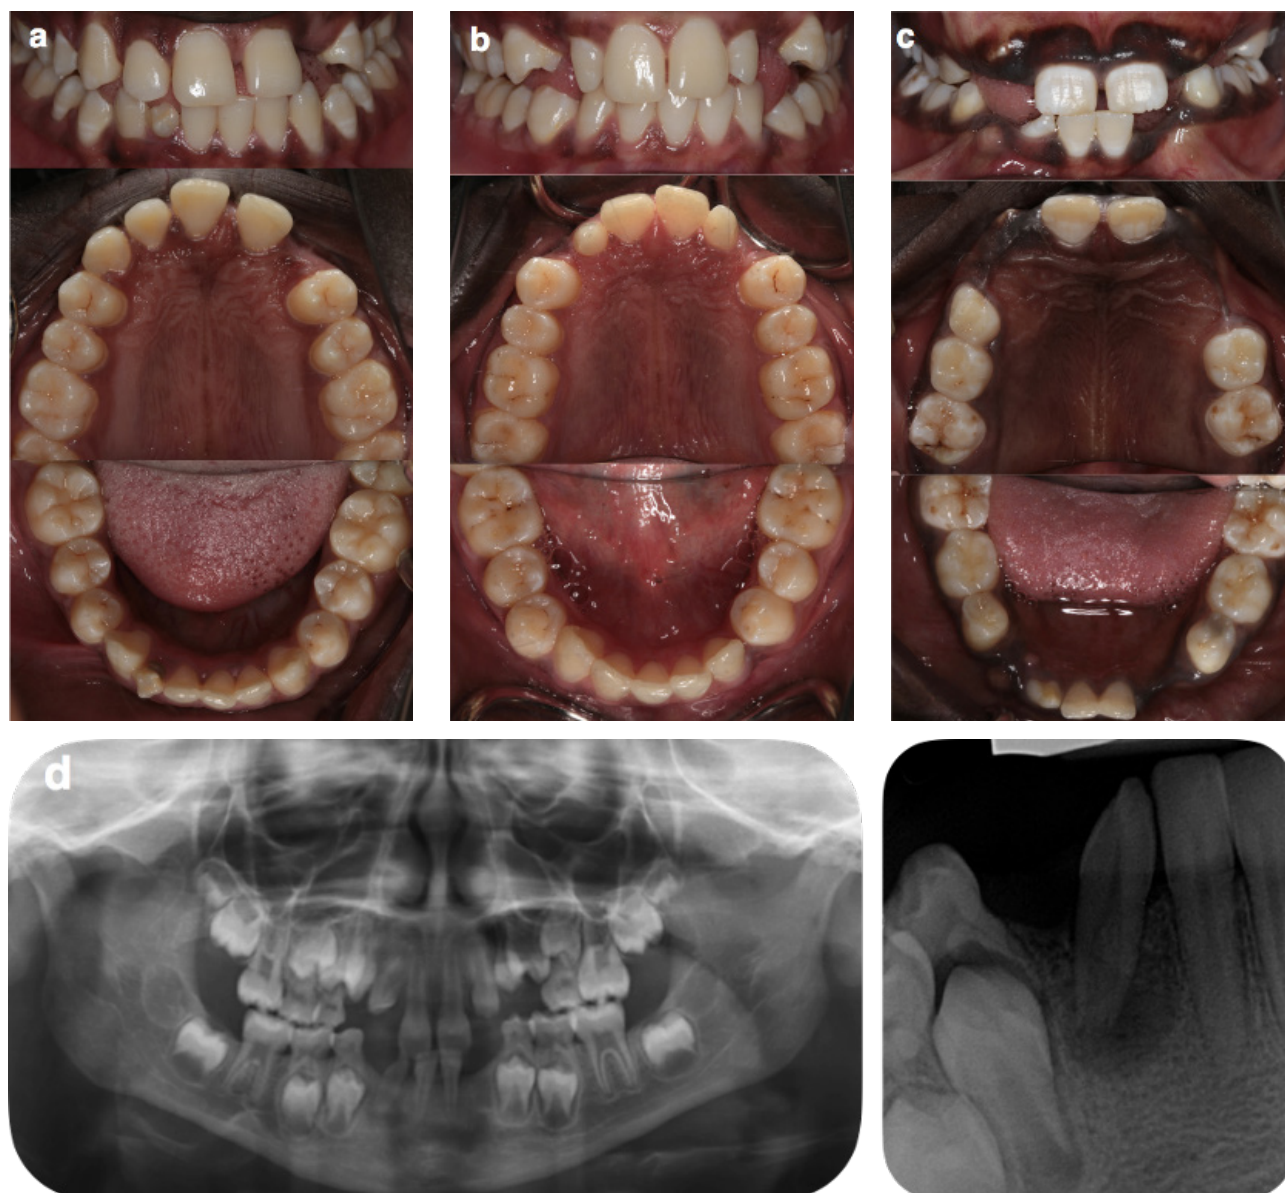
a) A 13-year-old girl presenting with missing teeth 22, 23 and malformed tooth 42 with subsequent malocclusion. b) a 16-year-old boy presenting with missing teeth 13, 23, 33 and incidentally microdont teeth 12 and 22. c) A 9-year-old girl presenting with multiple missing anterior teeth and malformed tooth 42 with dento-alveolar abscess. d) Radiographic investigation of Case C, revealing missing permanent teeth 32, 33, 43 and a conical structure of tooth 42 with an immature apex and associated radiolucency.
